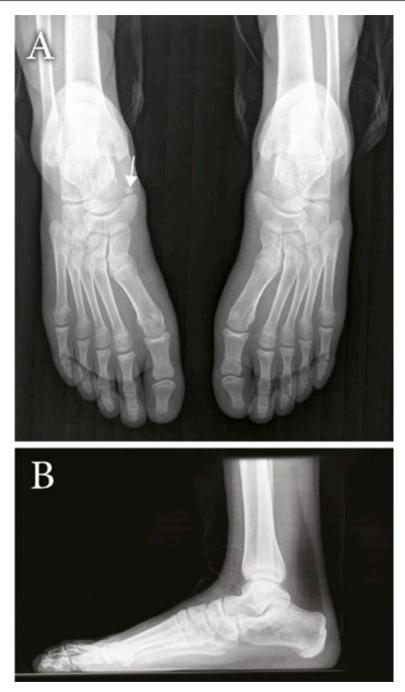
14-year old boy with accessory navicular type II (arrow) associated with normal arch. A: AP-radiograph shows no midfoot pronation or forefoot abduction. B: lateral weight-bearing radiograph shows no hindfoot equinus.
